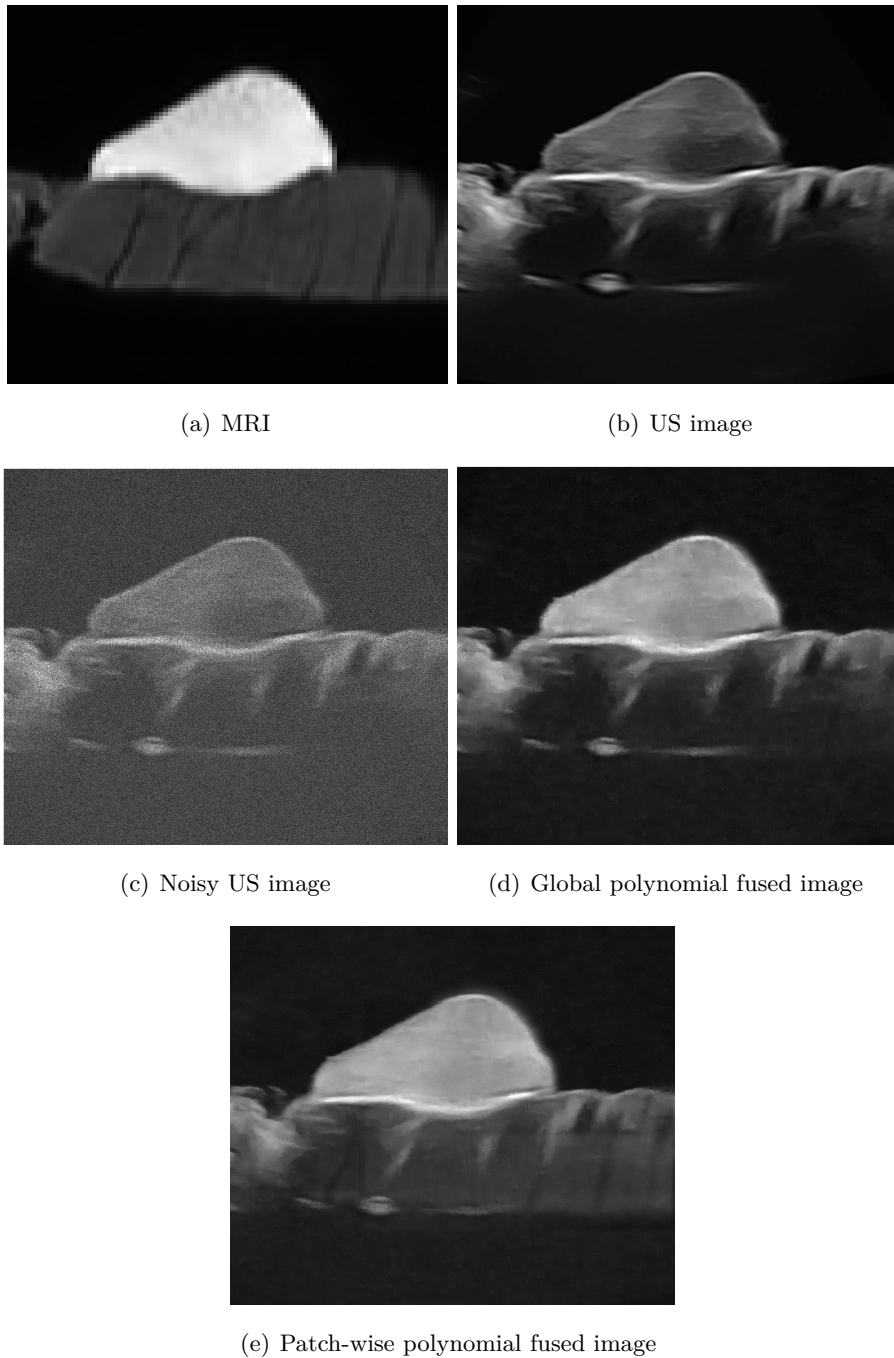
Original MR image ( $200 \times 200$  pixels) and US image ( $600 \times 600$  pixels) and fusion results: (a) observed MRI, (b) original US image, (c) noisy US image, (d) fused image using a global polynomial model, (e) fused image with the proposed path-based polynomial model.
